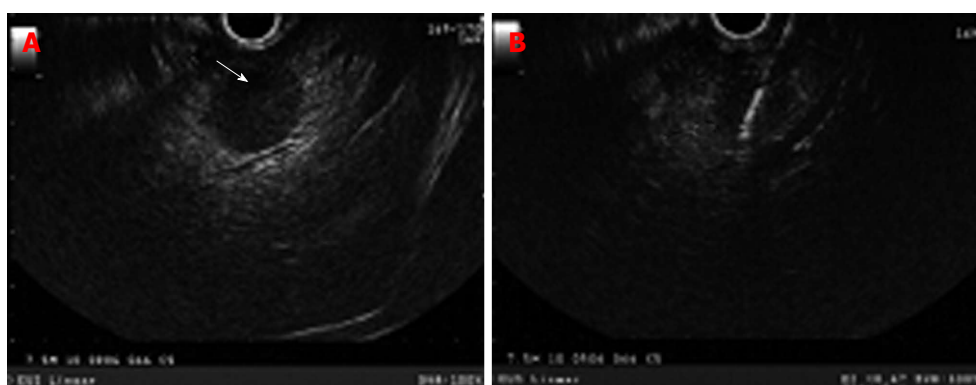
Hyperechoic rounded liver lesion (white arrow) representing a metastasis in patient with pancreatic neuroendocrine tumor with biliary obstruction and dilated intrahepatic duct (A); endoscopic ultrasound-guided fine needle aspiration of liver lesion using 22 gauge needle (B).
